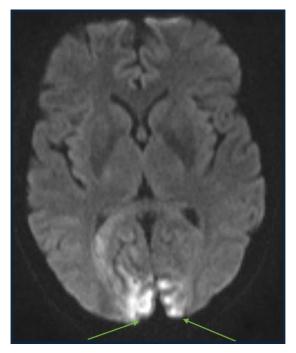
Axial DWI MRI Brain showing bilateral occipital infarcts.
